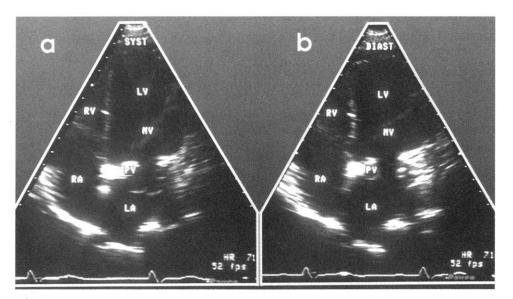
Apical 4-chamber echocardiographic view of the pulmonary autograft in the mitral position 6 years after the operation. A, Systolic frame. B, Diastolic frame. LA, Left atrium; LV, left ventricle; MV, mitral valve; PV, pulmonary autograft in mitral position; RA, right atrium; RV, right ventricle; HR, heart rate.
